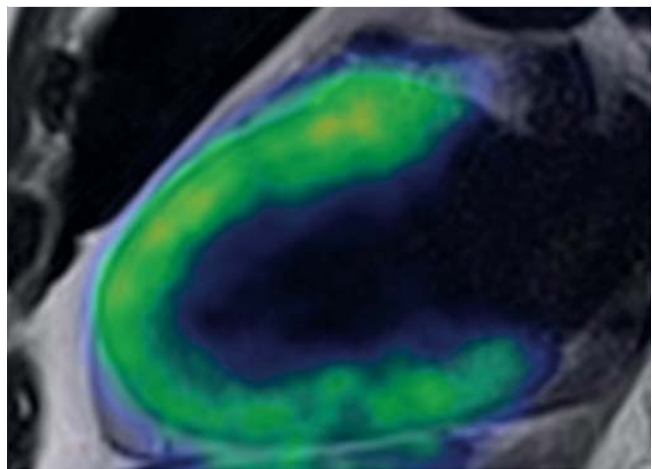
Fused 2-chamber view from a T2-weighted MR image and a simultaneous PET examination with ^{124}I -metaiodobenzylguanidine (MIBG). MIBG is a norepinephrine analogue that accumulates via a pre-synaptic re-uptake mechanism in the adrenergic nervous system. This enables a quantitative and morphologically detailed evaluation of the integrity and function of the adrenergic nervous system in diseases such as cardiac failure or diabetic cardiovascular autonomic neuropathy.
